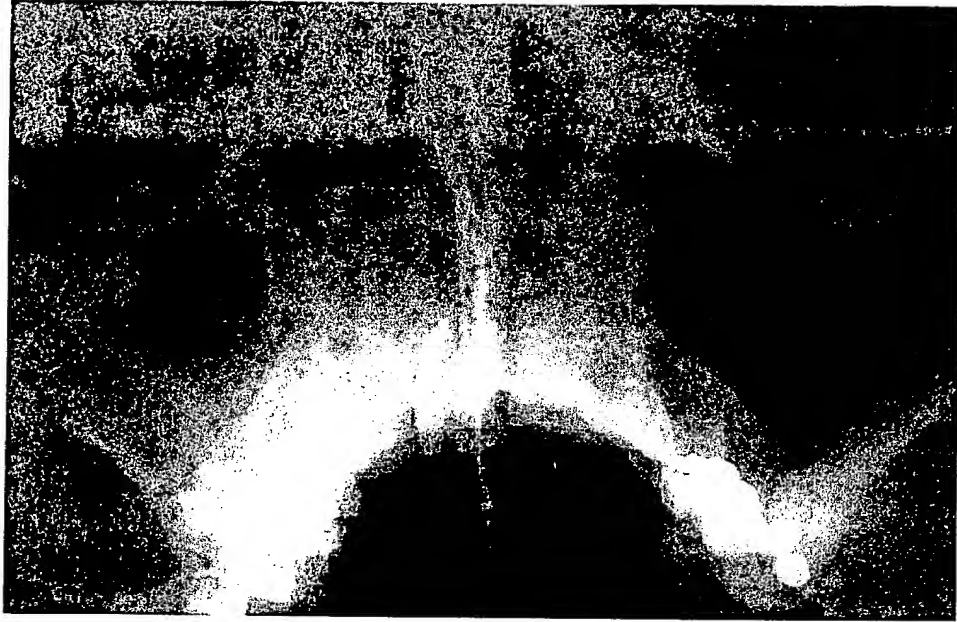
Photographs of X-ray Paranasal sinuses (PNS) of a 42 years old male patient, with a 15 years history of allergic rhino-sinusitis. Figure 1: X-ray PNS shows thickening of the mucosal lining of the right maxillary antrum and bilateral hypertrophy of nasal turbinates, patient treated by conventional therapy.
